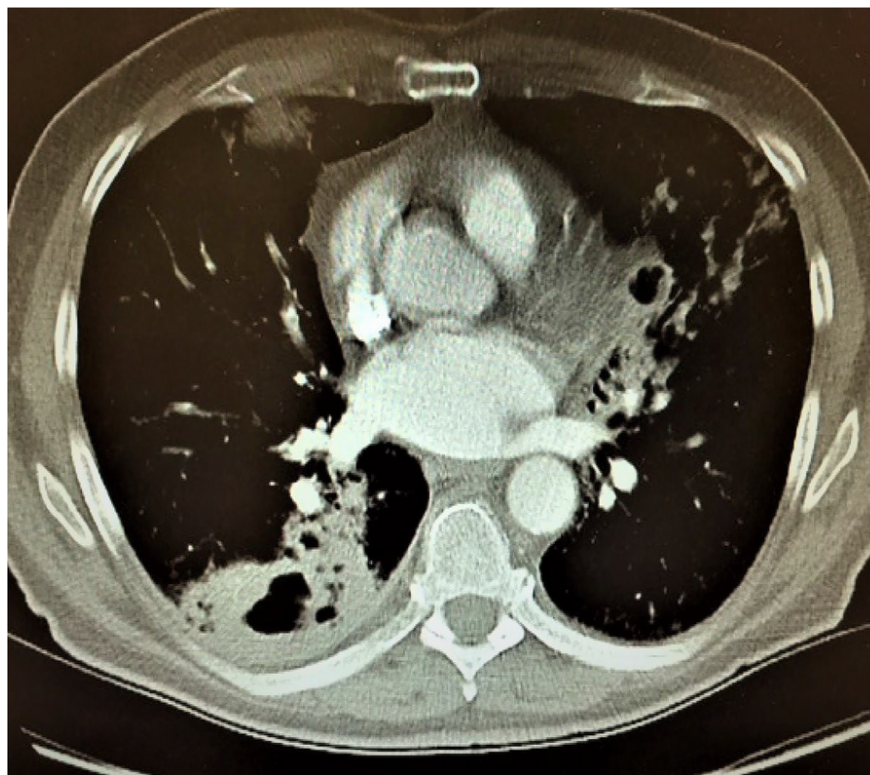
The high-resolution computed tomography (HRCT) after intravenous contrast injection in the late phase revealed a thrombus in the left superior pulmonary vein.
